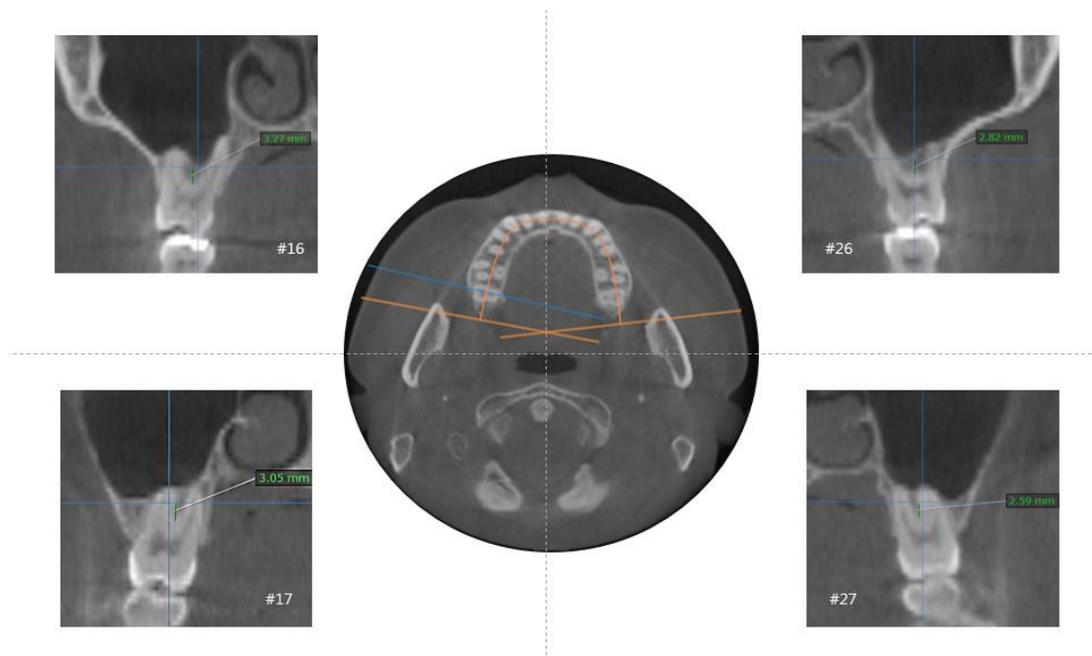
Cross sectional CBCT images were reconstructed perpendicular to arch shape that was lined at the cervical level of the maxillary molars
